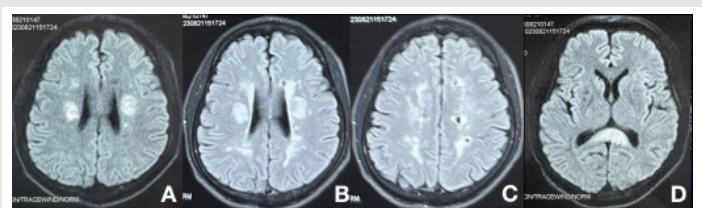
Acute cerebral infarction involving bilateral basal ganglia and centrum semiovale (DWI hyperintensity).
